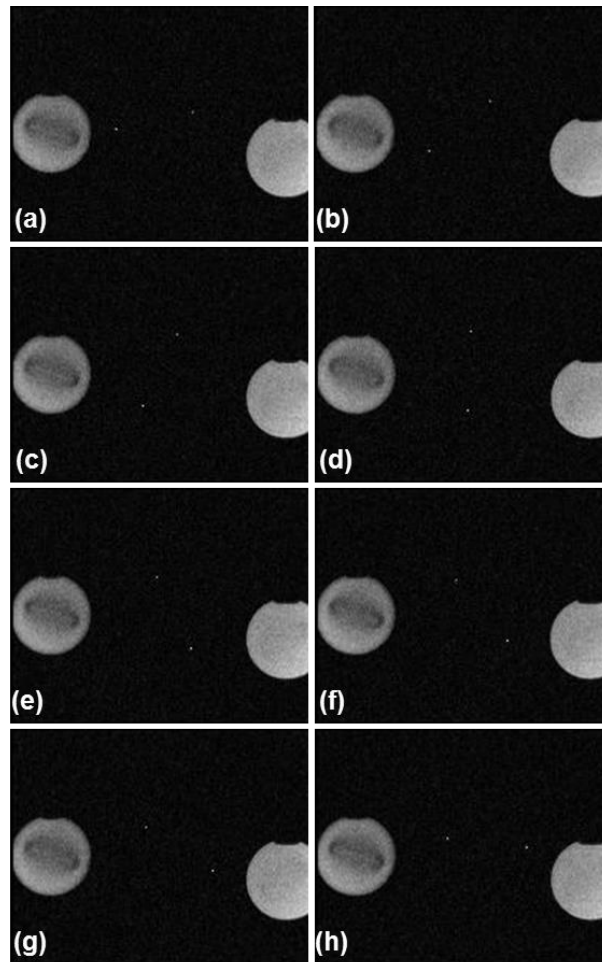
Transverse MR images acquired as DoF-3 translates.
